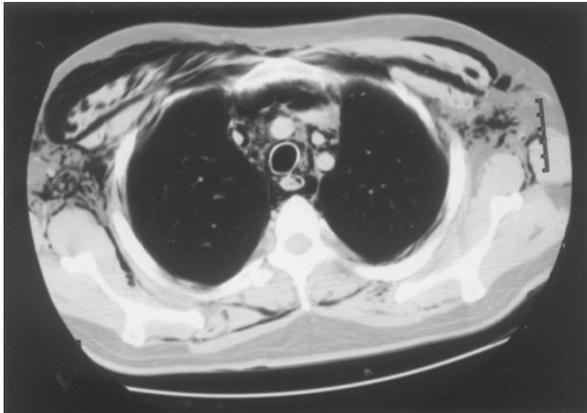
Computed tomography scan of the chest demonstrates a significant amount of air in the subcutaneous tissues and mediastinum.
